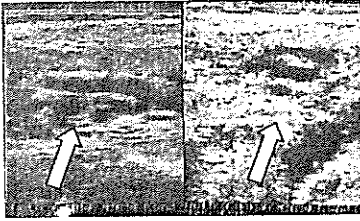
Ultrasonograms of the CL of Pregnancy. Note the 1st form as compact central hypoechoic area.
